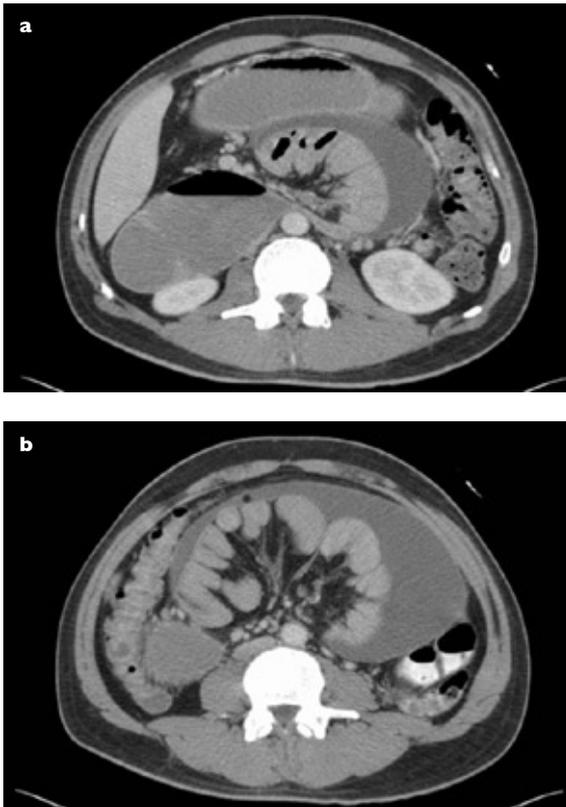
Axial CT images (a,b) show encapsulated small bowel loops within a large fluid loculation and the colon.
